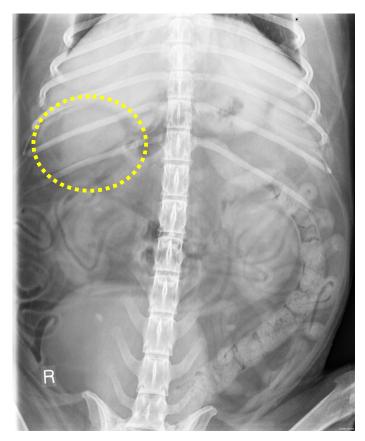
Abdominal radiography. Ventro-dorsal view.
